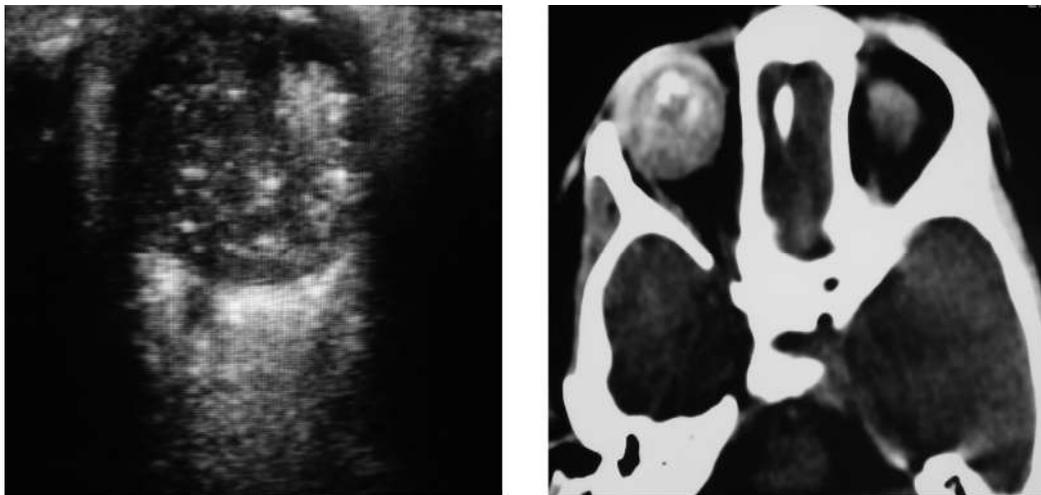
Retinoblastoma – Intra-ocular soft tissue mass lesion with foci of calcifications on USG (left) and CT (right)
